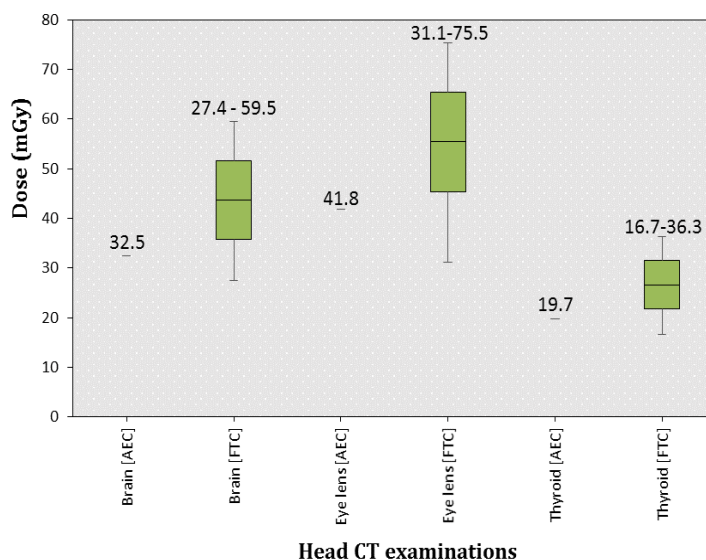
Organ doses for head computed tomography examinations
